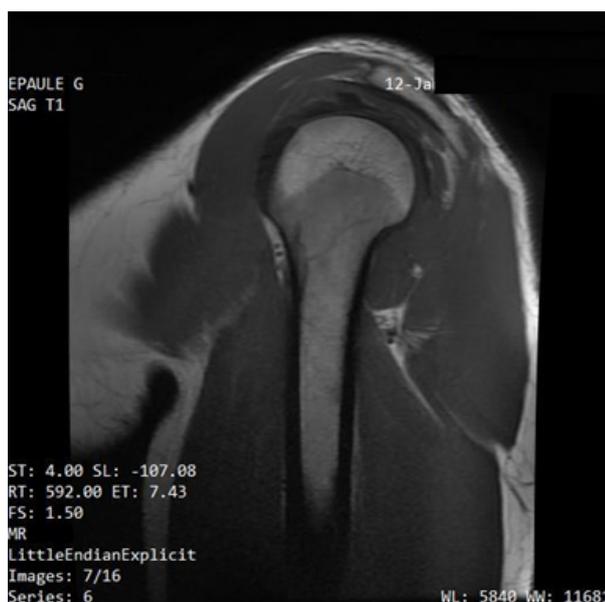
MRI of the left shoulder, sagittal T1-weighted view: hypointense signal of the subacromial-deltoid bursa (bursitis).
